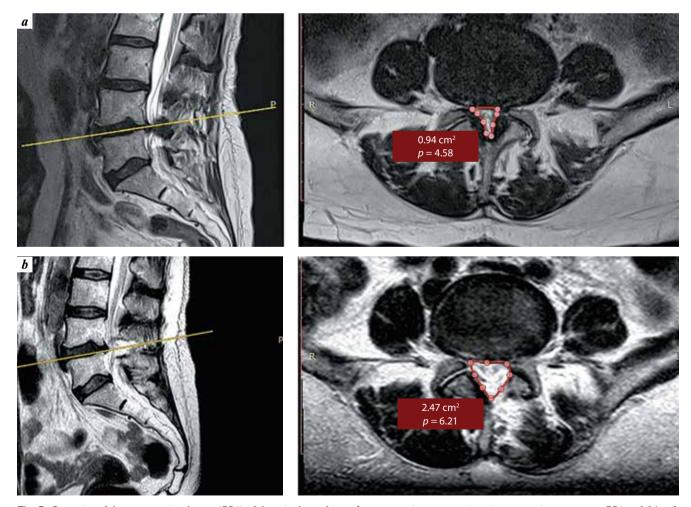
Dynamics of the cross-sectional area (CSA) of the spinal canal in  $cm^2$  per magnetic resonance imaging: a - prior to surgery: CSA = 0.94 cm<sup>2</sup>; b - on day 1 after endoscopic decompression: CSA = 2.47 cm<sup>2</sup>
